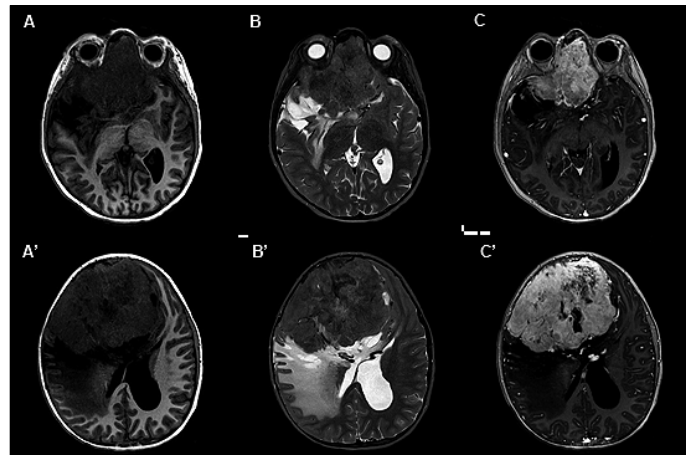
MRI: (A-A') T1W axial; (B-B') T2 axial; (C-C') T1W gadolinium -enhanced axial.
